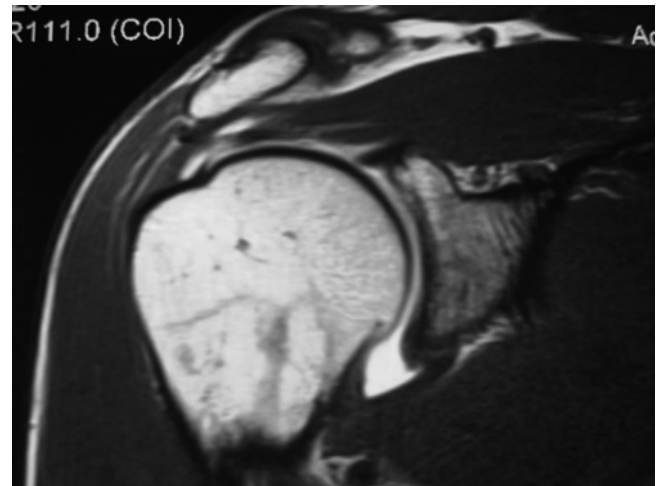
Partial intra-articular rotator cuff tear. An MRI image
